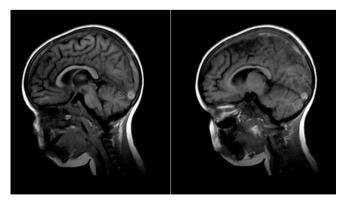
Sagittal view in T1-weighted sequence.
